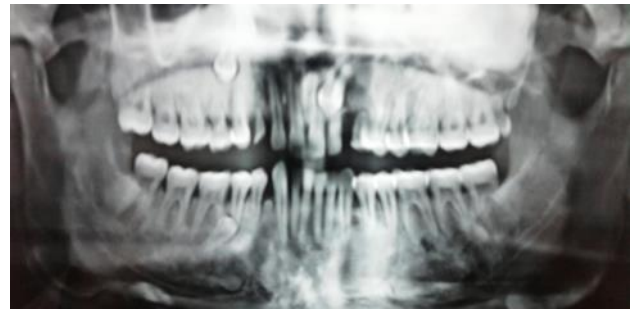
Dental Orthopantomogram.
